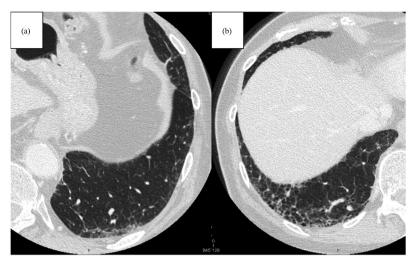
Axial CT scans showing subtypes of interstitial lung abnormalities based on the presence or absence of fibrosis. (a) Non-subpleural fibrotic interstitial lung abnormalities (non-SF-ILAs). (b) Subpleural fibrotic interstitial lung abnormalities (SF-ILAs).
